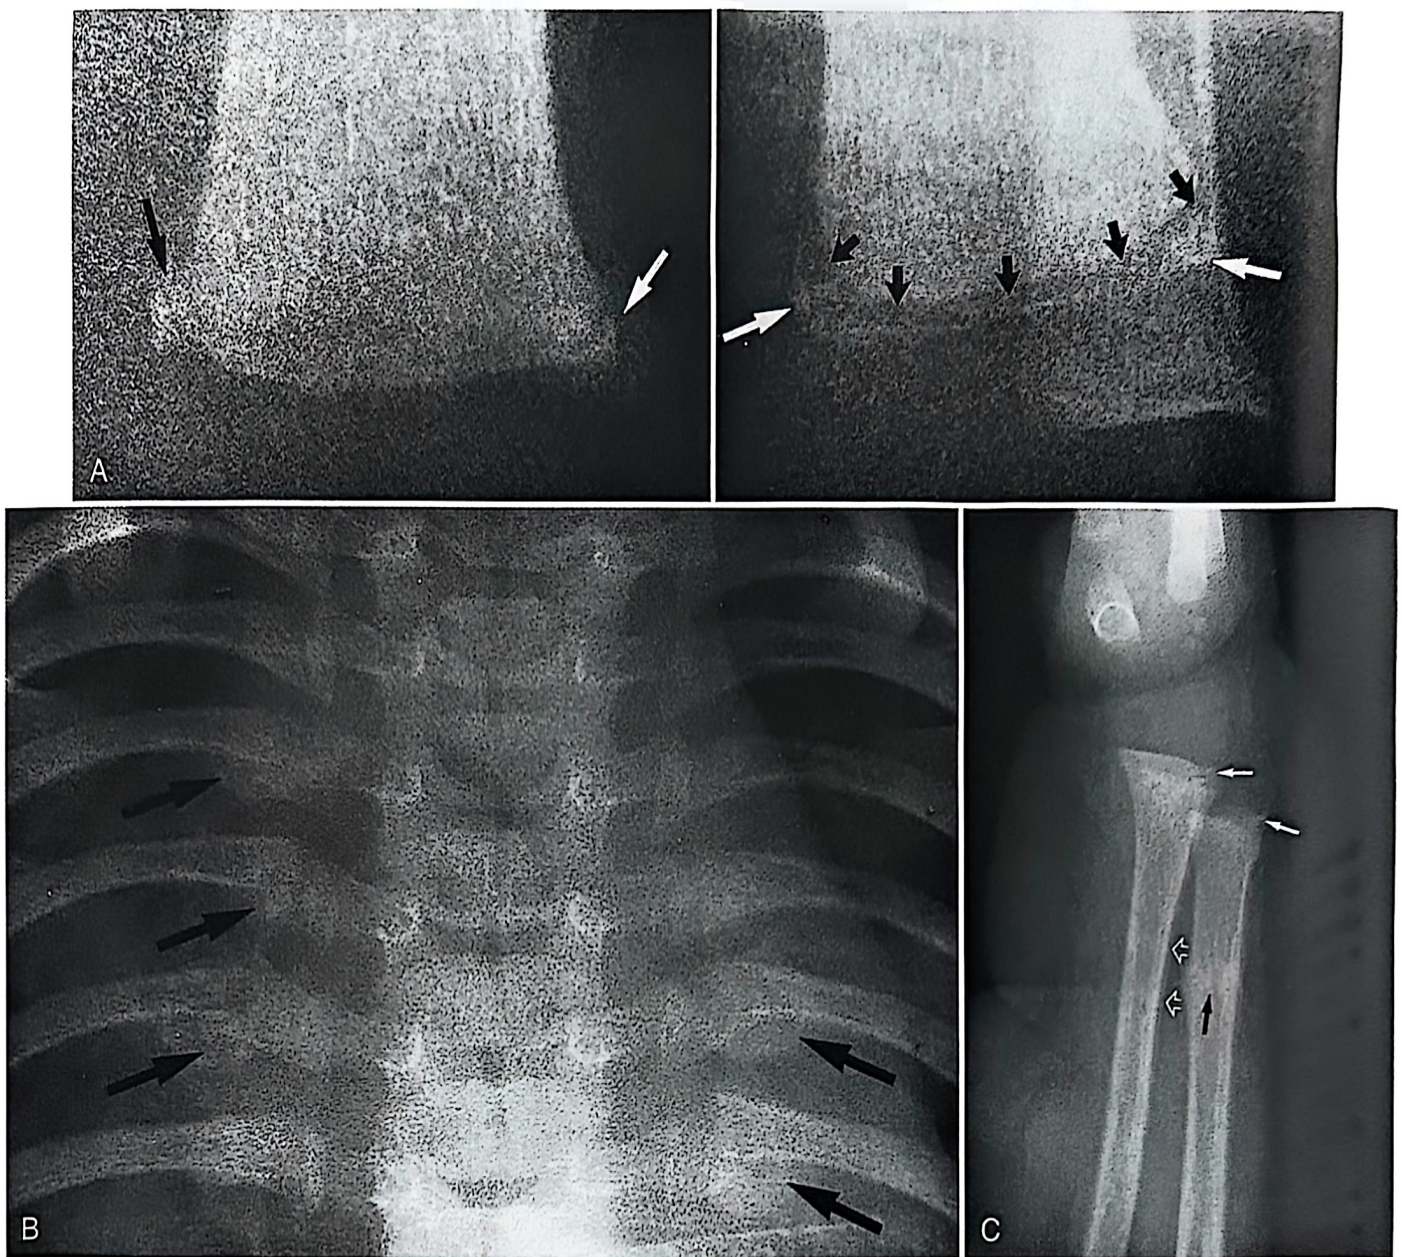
Nonaccidental trauma. (A) Distal tibiae revealed periosteal reaction from repeated bruising of the bone. (B) Skeletal survey revealed five healing rib fractures (*arrows*). (C) Four months later, the patient was treated for fracture of the forearm. Radiographs revealed evidence conflicting with the parent's report of trauma.
